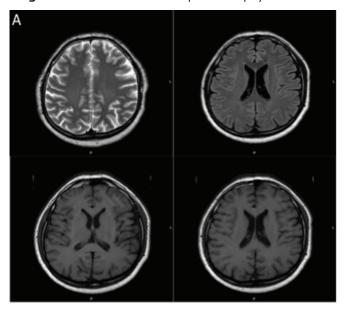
MRI shows left temporal atrophy
